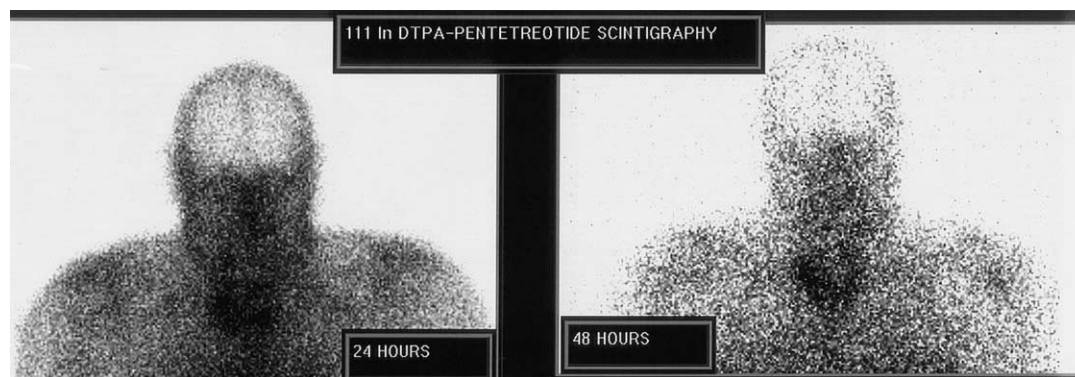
Postoperative ^{111}In -DTPA-Pentetreotide scintigraphy (Octreoscan) showing an elective uptake at the right thyroid lobe.
